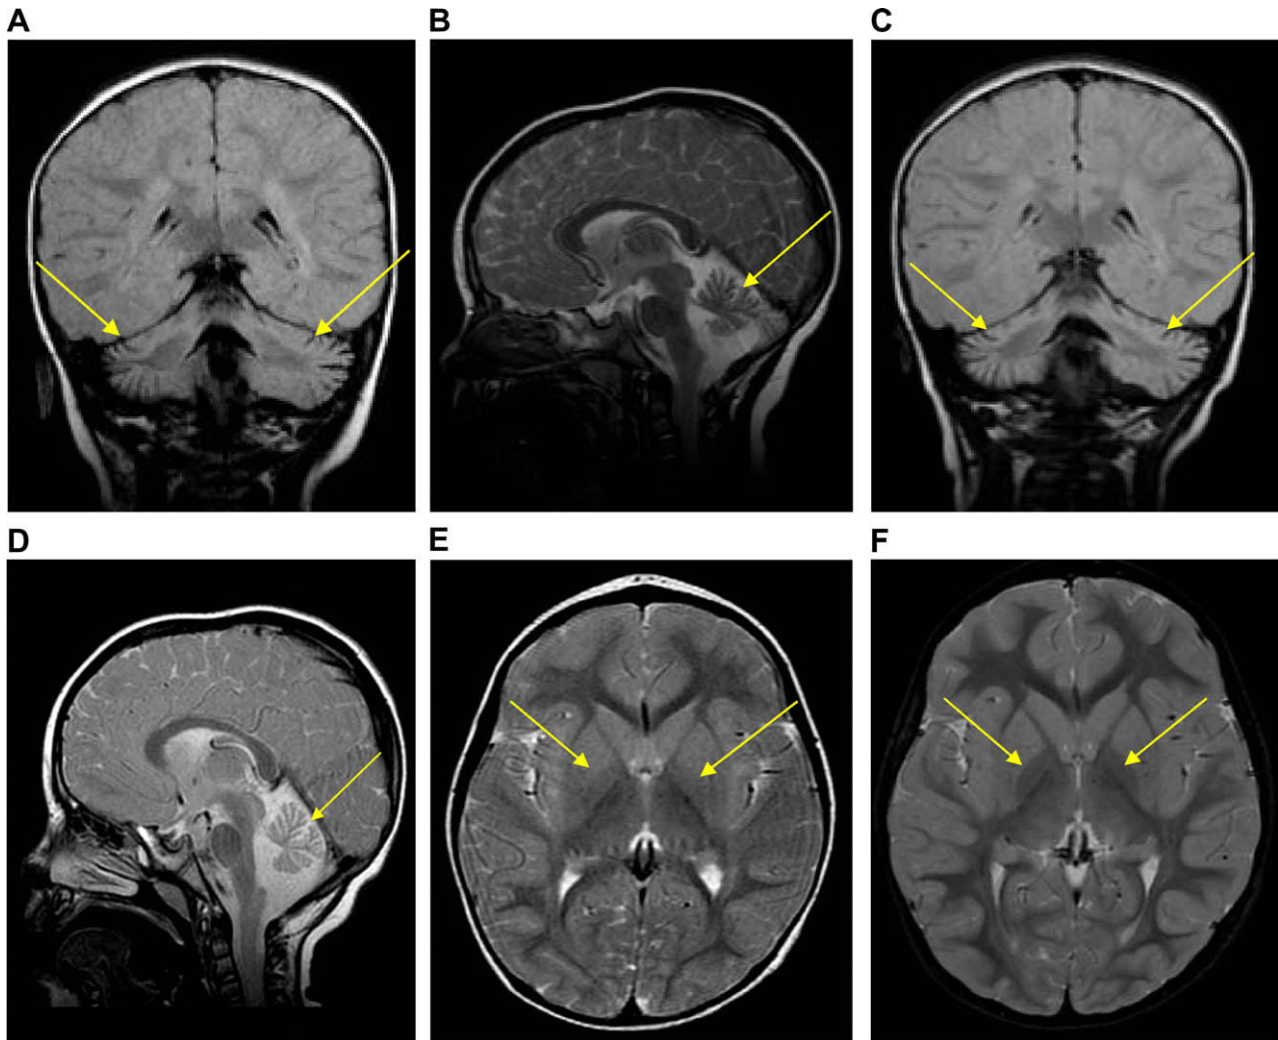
MRI brain scan of patient 1. (A) and (B) Patient 1, age 2 years. (C) and (D) Patient 1, age 2.9 years. MR imaging. (E) Patient 1, age 2.0 years and (F) patient 1, age 2.9 years. (A) Coronal FLAIR sequence showing cerebellar atrophy, but no cerebellar grey matter gliosis. (B) Sagittal T2-weighted imaging showing marked atrophy of the cerebellar vermis. (C) Coronal FLAIR sequence shows cerebellar atrophy which is slightly worse than shown on previous scan at age 2 years (1A). Still no gliosis/abnormal signal is evident in the cerebellar grey matter. (D) Sagittal T2-weighted imaging showing marked atrophy of the cerebellar vermis. (E) Axial T2-weighted image showing very subtle decrease in T2 signal (compared to normal age-matched controls) in the globus pallidi. (F) Axial T2-weighted image showing further reduction in T2 signal within the globus pallidi.
